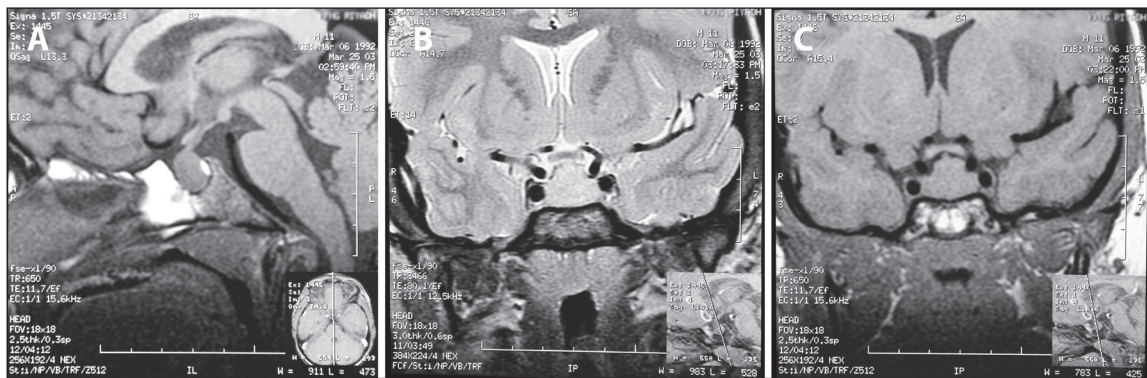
MRI of pituitary gland A) sagittal view, B) coronal view, and C) with contrast (coronal view).
